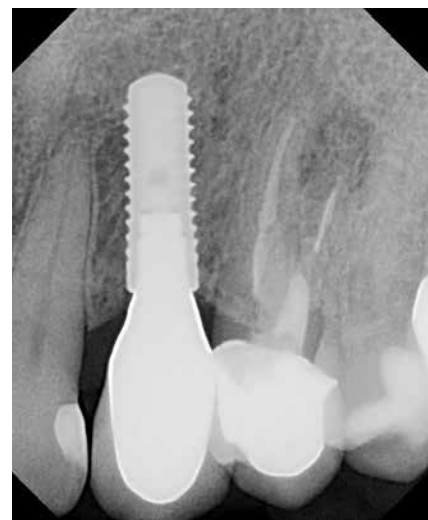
No radiographic bone loss was noted.
